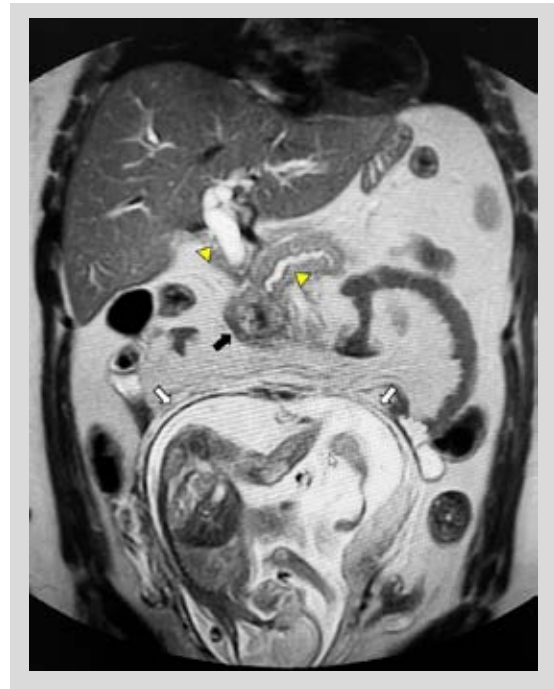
Non-contrast abdomino-pelvic T2-weighted coronal MRI demonstrating a 4-cm solid mass at the pancreatic head (black arrow) with marked dilatation of the common bile duct and the main pancreatic duct (yellow arrowheads). A 24-week gravid uterus with a normal fetus can also be seen (with the arrows).
